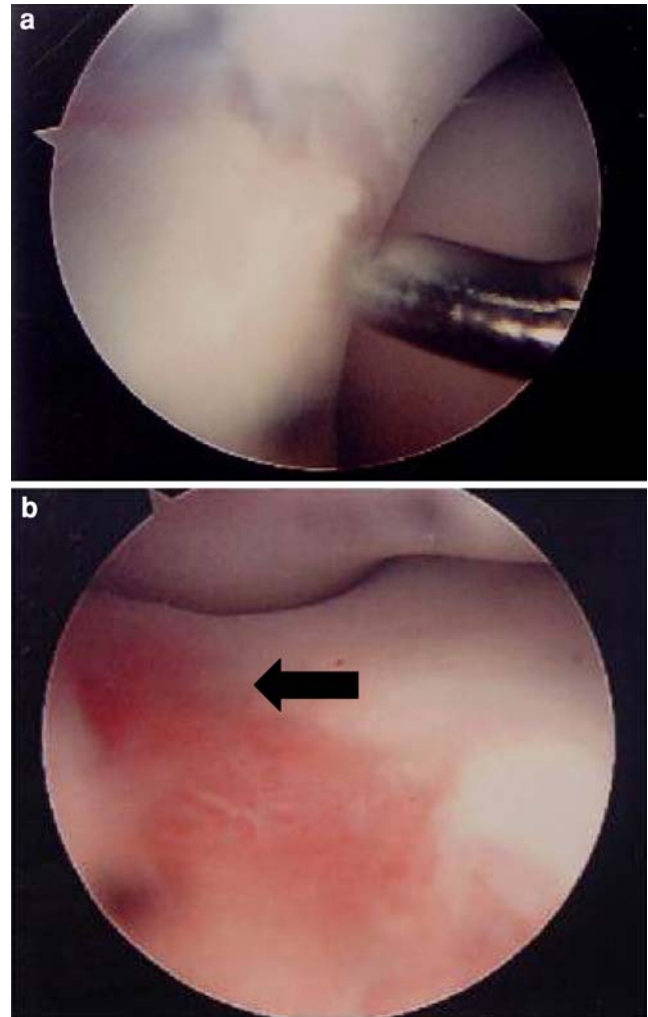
a Right elbow arthroscopy revealed proper fracture healing compatible with the radiographic findings. A *transparent line*, resembling fibro-cartilage tissue was noted over the olecranon stress fracture site. b A chondromalacia lesion, about $0.5 \times 1.0 \text{ cm}^2$ with irregular chondral margin, was found on the articular surface of trochlear notch. (*Black arrow*)
